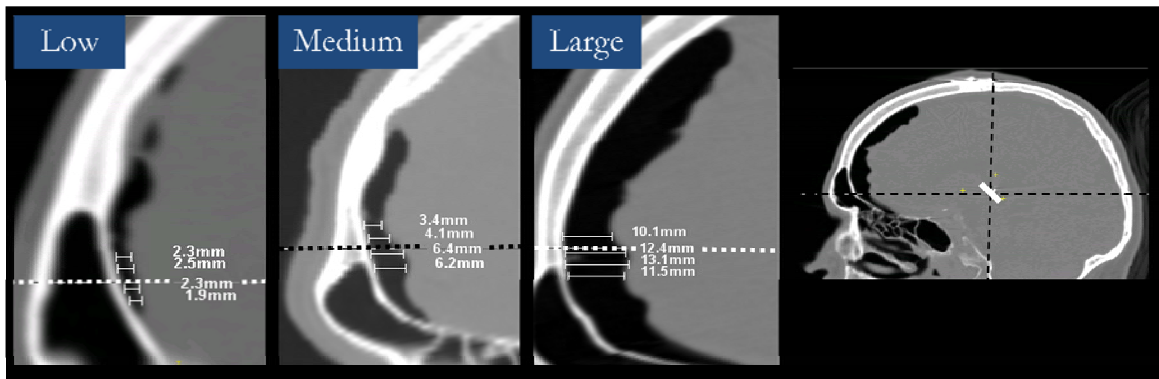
Sagittal slices containing the final implant for low-, medium- and large-shift patients classified based on the width of the air pocket in the immediate CT.
